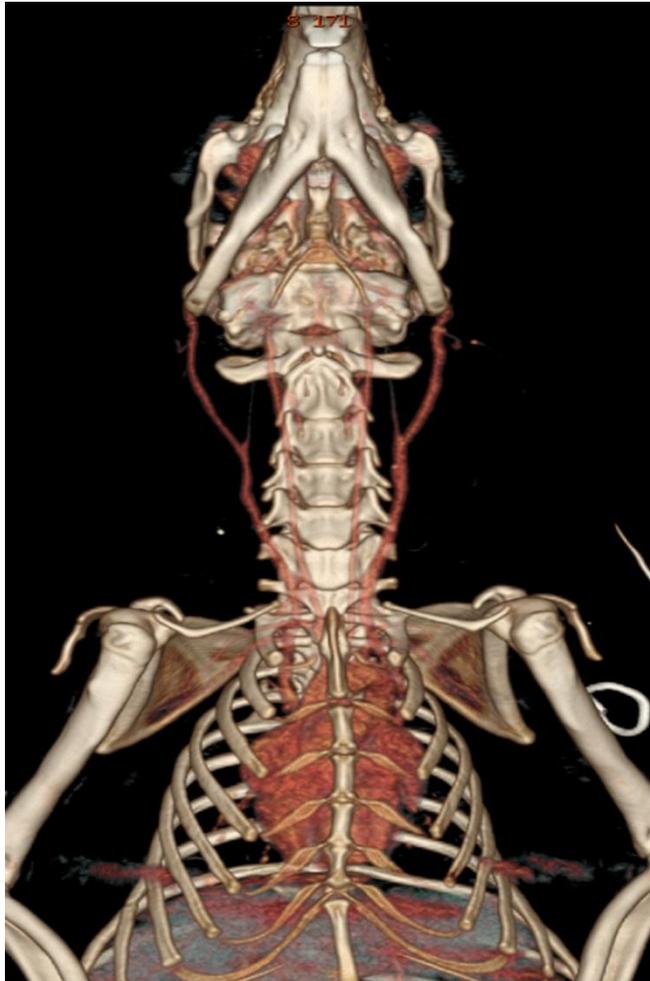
Three-dimensional reconstruction of vascular structures using computed tomography. The patency of both external jugular veins was maintained without narrowing.
